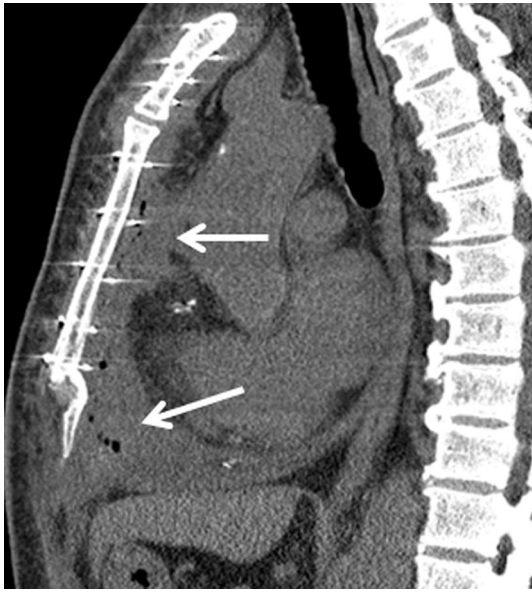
Acute mediastinitis in a 52-year-old man treated with coronary artery bypass graft surgery. Sagittal CT image on POD 25 shows fluid collection with multiple air pockets (arrows) in anterior and mid mediastinum
